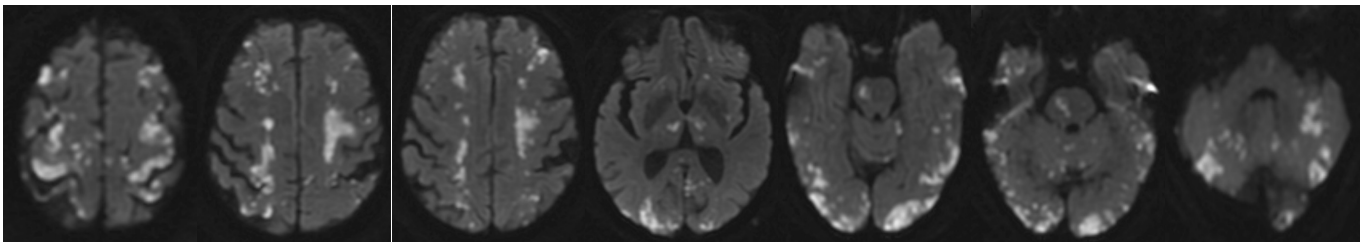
Repeat MRI in 24 hours, after worsening neurological exam.
